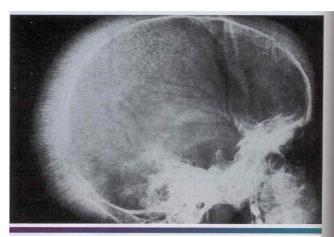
• Thalassemia. Lateral skull radiograph depicting the characteristic "heir-on-end" appearance in a patient with thalassemia.
